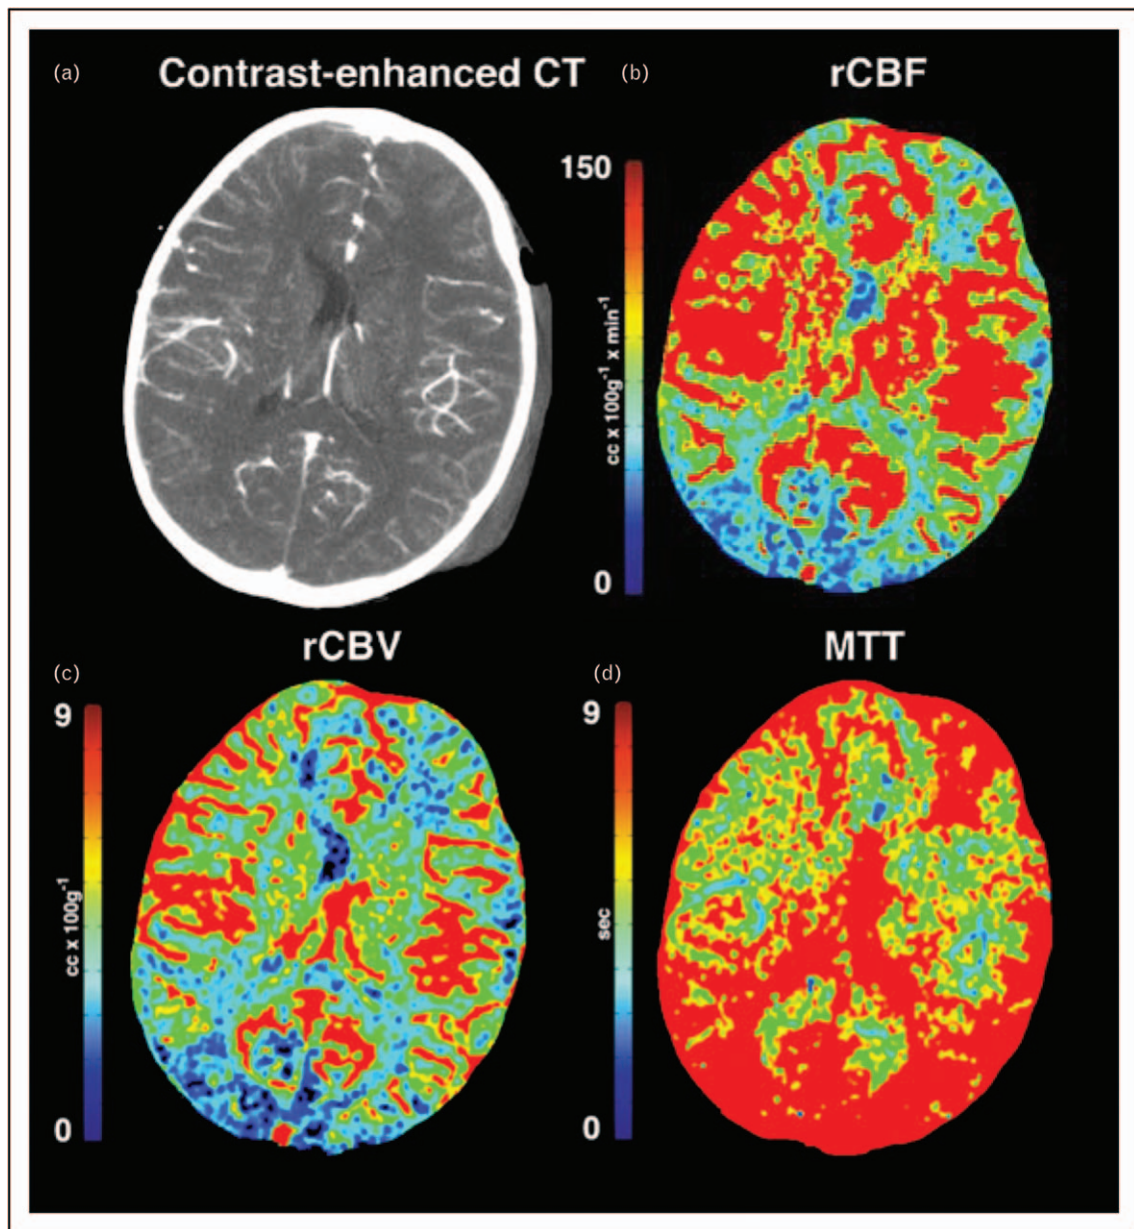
Contrast-enhanced and perfusion computed tomography images of a case of traumatic brain injury with intracranial hypertension. The contrast enhanced computed tomography (a) demonstrated left-sided scalp hematoma. The regional cerebral blood flow (b) and regional cerebral blood volume (c) trended toward lower values especially in the occipital lobes. The mean transit time (d) demonstrated significantly higher values, reflecting altered cerebral autoregulation after traumatic brain injury. Reprinted with permission [37*].
